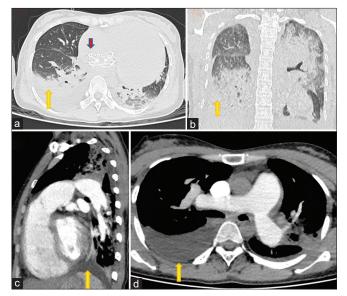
Computed tomographic scanning of the chest in (a) axial, (b) frontal view showing evidence of pleural effusion (yellow arrow), lung collapse and features suggestive of pulmonary edema. The atrial septal occluder is marked with red arrow (a) CT pulmonary angiogram in sagittal and axial view showing dilated right ventricle (c), dilated pulmonary artery with no evidence of thrombus (d) and significant pleural effusion in the right side (yellow arrow). CT : Computed tomography
